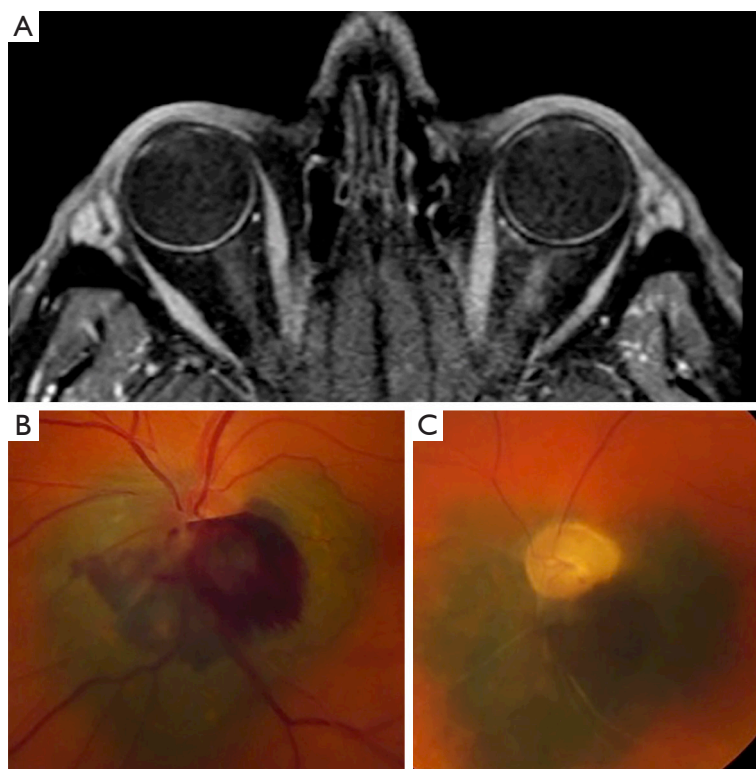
Radiation optic neuropathy three years post treatment in a 53-year-old male who received 50 Gy in five fractions for a choroidal melanoma. (A) T1 post-contrast fat-suppressed MRI of the orbits with gadolinium enhancement demonstrating optic nerve enhancement of the left eye. (B) Fundus photography of the left optic nerve demonstrating a choroidal melanoma surrounding the optic nerve with overlying optic disc hemorrhage prior to radiation treatment. The visible portion of the optic nerve appears pink. (C) Fundus photography of the left optic nerve three years after radiation treatment with subsequent pallor and atrophy of the optic nerve. This eye lost all vision. MRI, magnetic resonance imaging.
